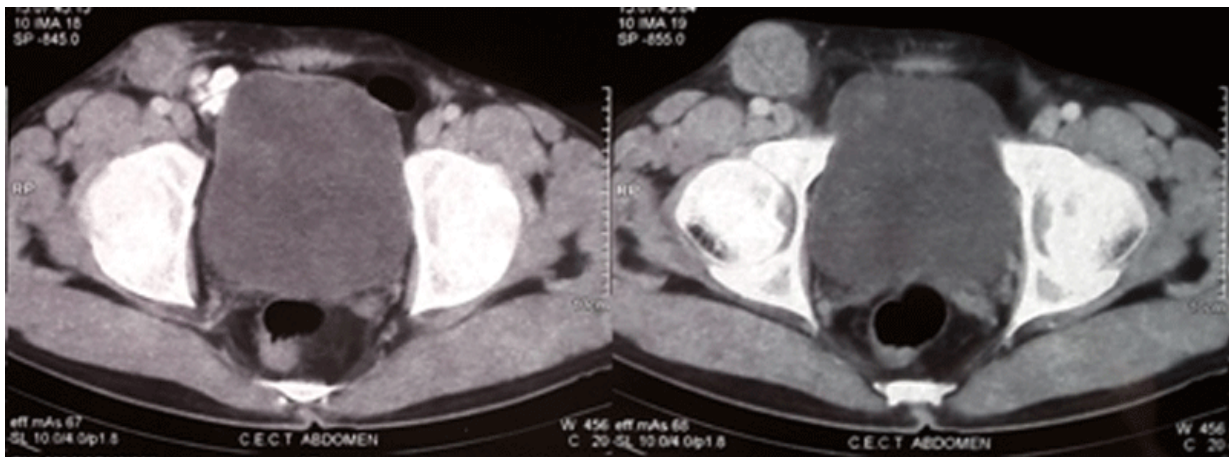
Computed tomography pelvis showing nodal mass involving right inguinal region
